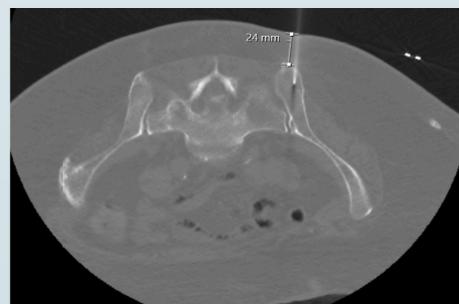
Single axial CT fluoroscopic acquisition in bone window demonstrating the calculation of skin to bone distance of a patient undergoing bone marrow biopsy in prone position
